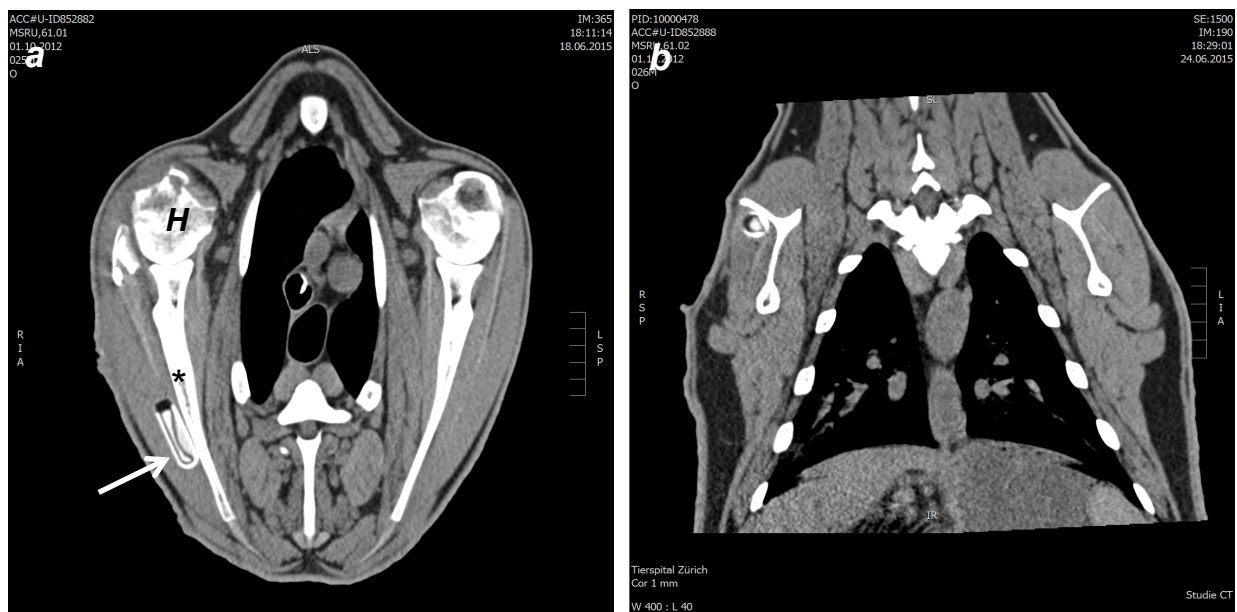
CT scans showing the infraspinatus muscle on both sides, the operated and the control side. The pump is situated on the operated right side (*arrow*), lying in the infraspinatus muscle belly, adjacent to the scapular spine (*asterisk*), *H* = Humeral head. (a) CT of the transverse plane. (b) CT of the coronal plane.
